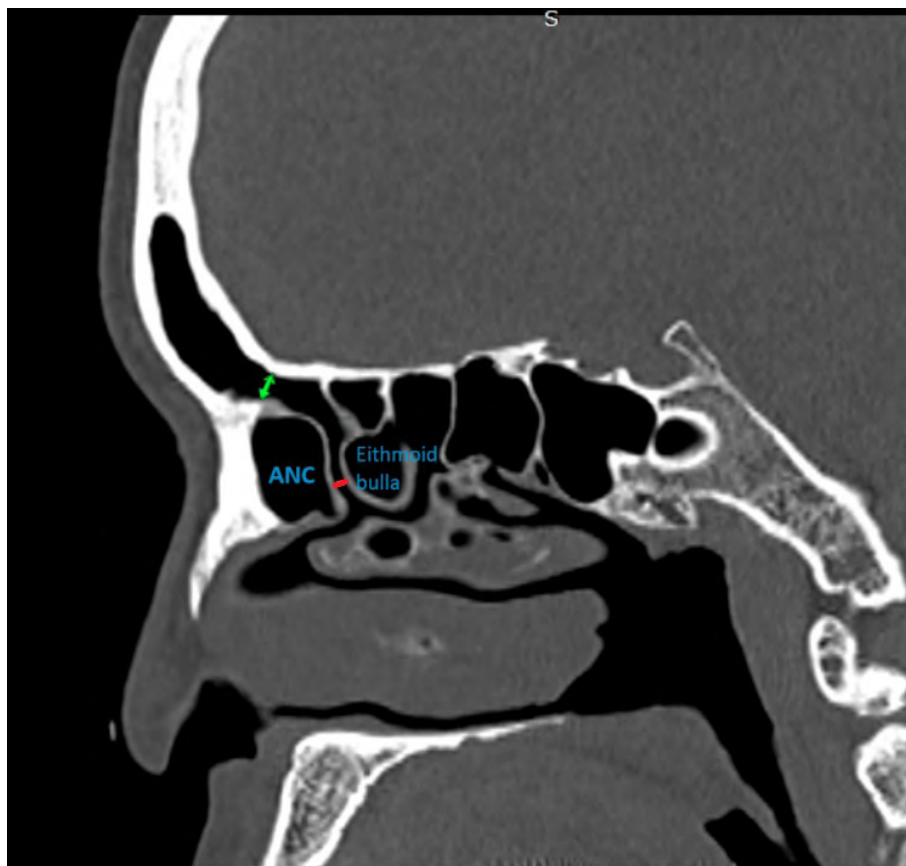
Non-contrast parasagittal computed tomography (CT) image of the paranasal sinus, showing the frontal sinus ostium (green double-headed arrow) and the frontal recess (red line) measured from the posterior wall of the agger nasi anteriorly to the ethmoidal bulla posteriorly.
